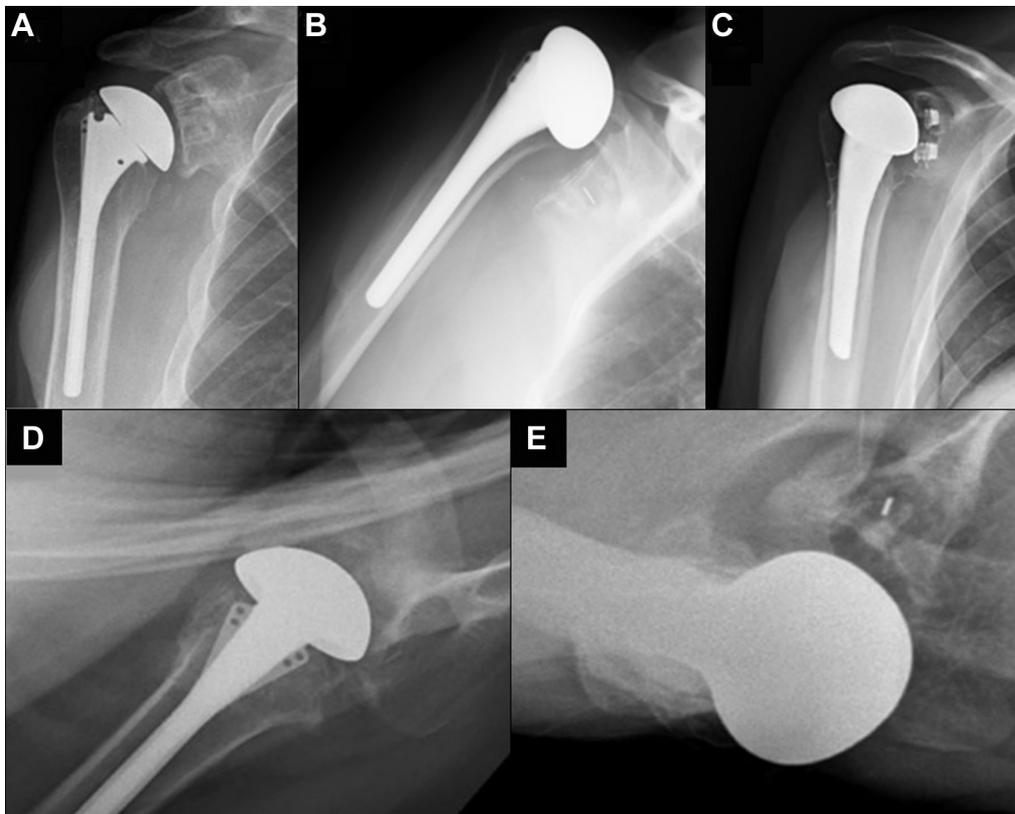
Radiographic evaluation of glenohumeral registry: normal (A), superior (B), medial (C), anterior (D), and posterior (E).
